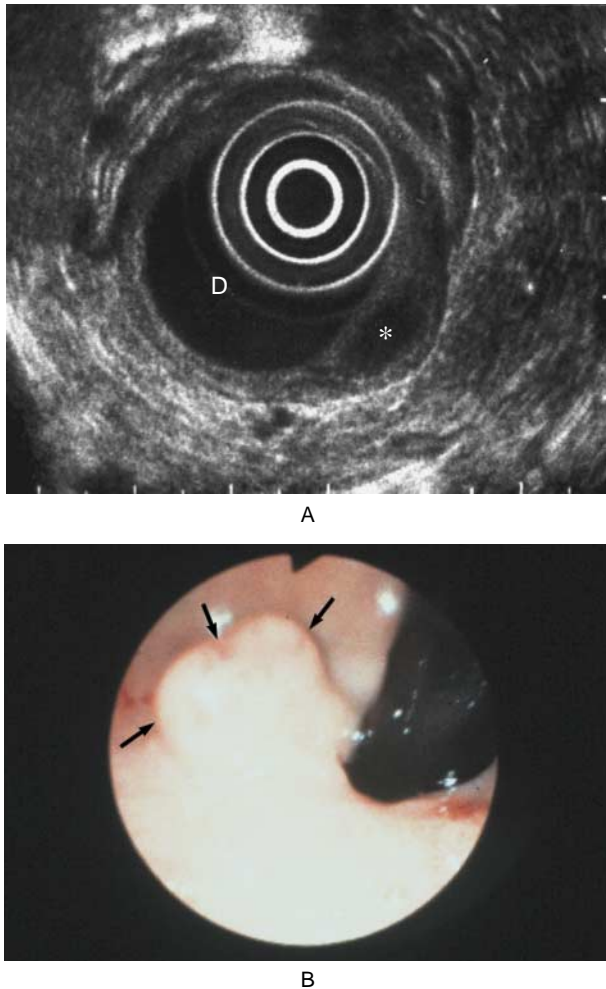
Endosonographic and Endoscopic Images of the Gastrinoma.
